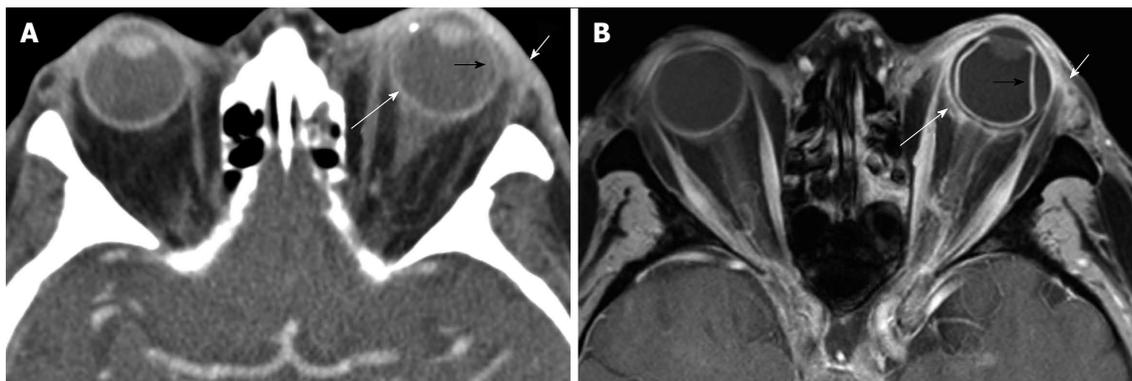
Periscleritic orbital inflammatory disease. Eighty-seven-year-old immunocompromised man with left eye pain and ordering indication of "cellulitis". A: Axial contrast-enhanced CT shows mild infiltration of the left periorbital fat (short white arrow). There is also periscleral edema (long white arrow), and subtle high density along the temporal surface of the globe that is suggestive of a subchoroidal fluid collection (black arrow); B: Axial fat-suppressed contrast-enhanced T1 shows these findings more conspicuously. Note that the elevated choroid layer (black arrow) extends anteriorly to the region of the ciliary body. Periscleral edema (long white arrow) extending to Tenon's capsule is better seen. CT: Computed tomography.
